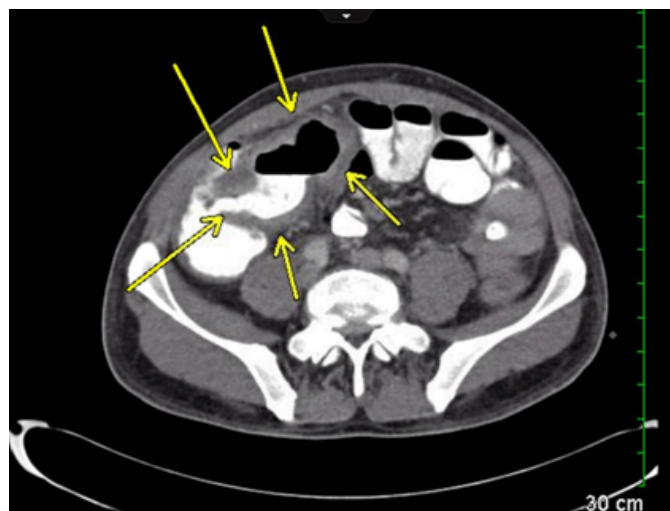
Cross sectional computed tomography scan of the abdomen showing from the furthest left arrow, cecum to thickening of terminal and distal ileum.
